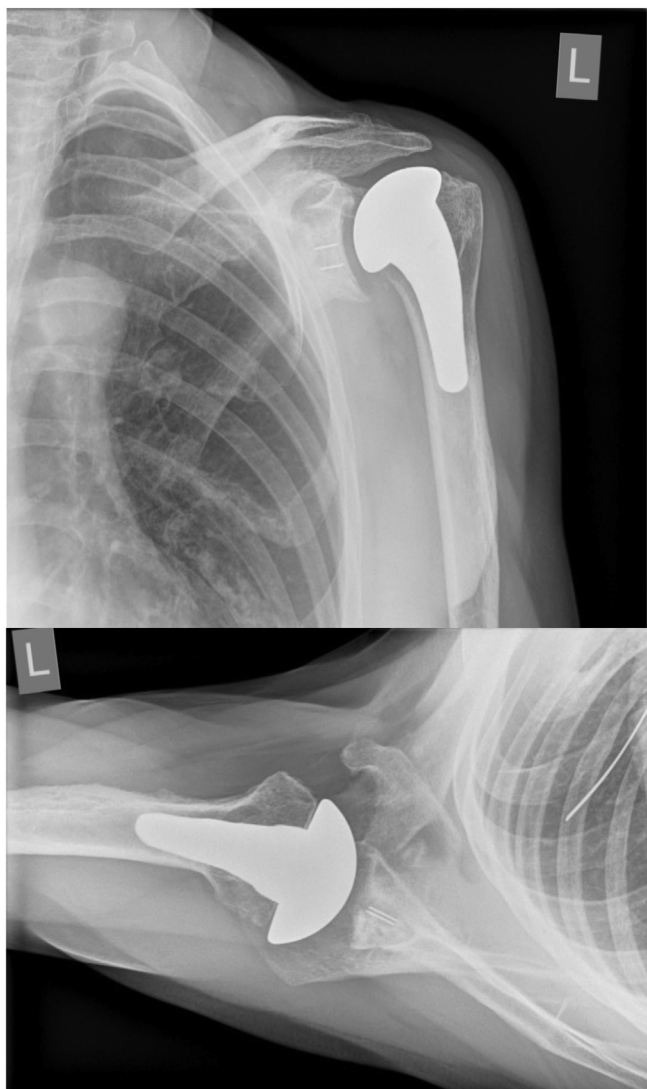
Postoperative X-rays.
